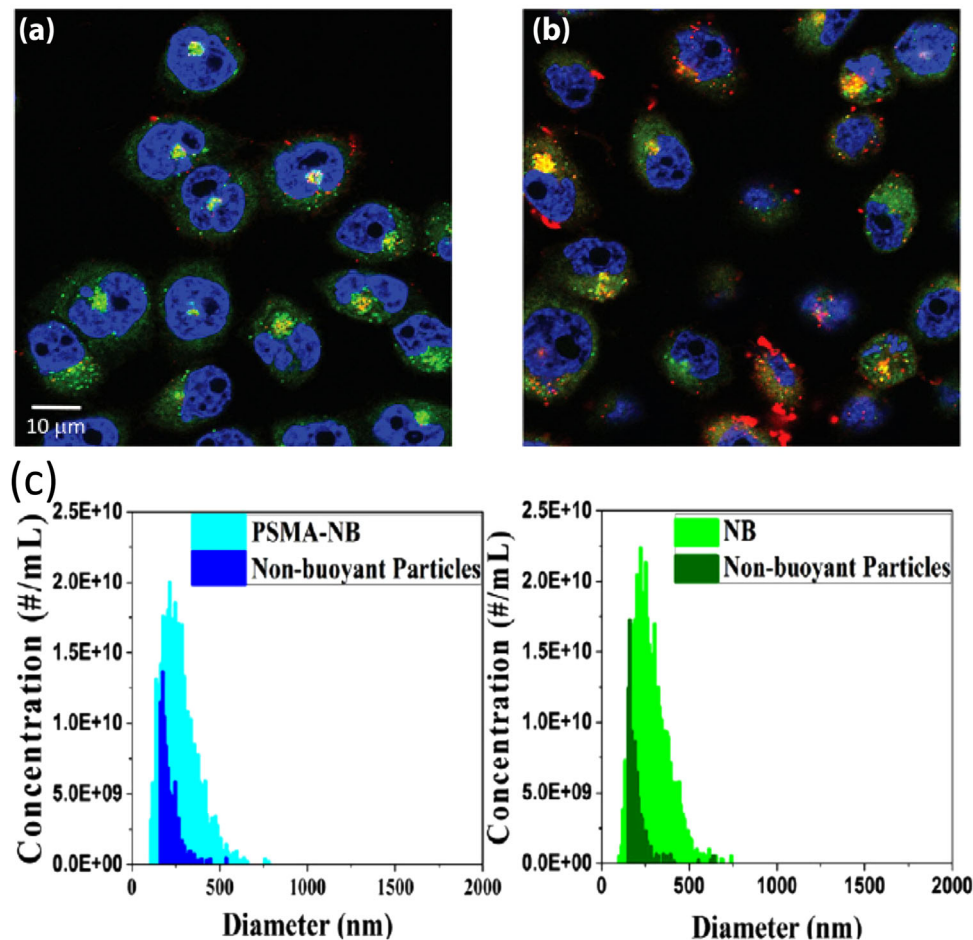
Representative confocal images of (a) NB and (b) PSMA-NB distribution in PC3pip cells. 100× (blue-nuclei, red-NB, and green-late endosome/lysosomes), yellow-co-localized bubbles in late endosome/lysosomes. PSMA-NB shows high co-localization in late endosomal/lysosomal vesicles (yellow). (c) Size distribution and the concentration of NBs and PSMA-NBs acquired via resonant mass measurement. Nonbuoyant particles refer to liposomes, micelles, lipid debris, and so forth.
